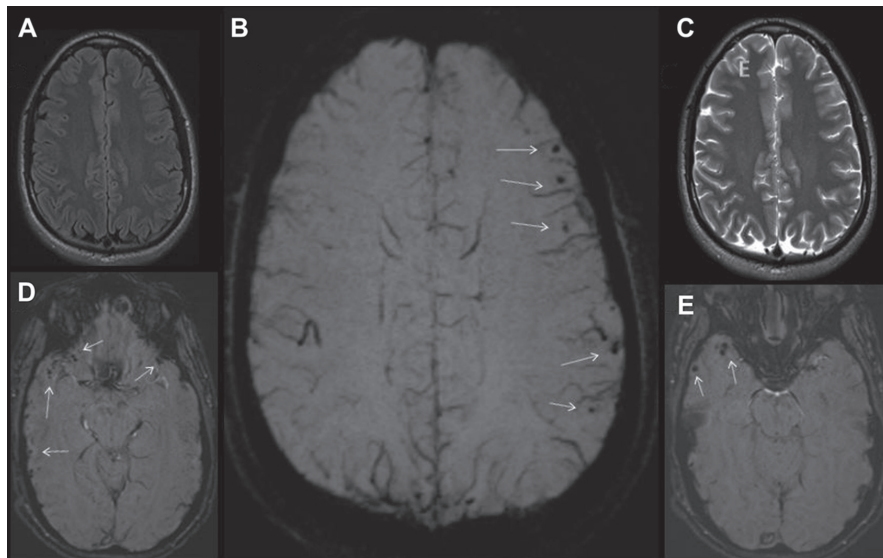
A 14-year-old teenager with mTBI and postconcussive symptoms secondary to a bicycle accident. (A) FLAIR and (C) T2-weighted images were unremarkable. (B, D, E) SWI images show microhemorrhages (*arrows*) in juxtacortical locations and in orbitofrontal and temporal lobes.
